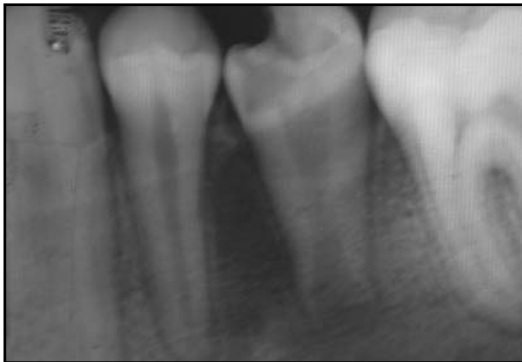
Initial radiographic image showing an open apex and periapical osteitic process in 35
